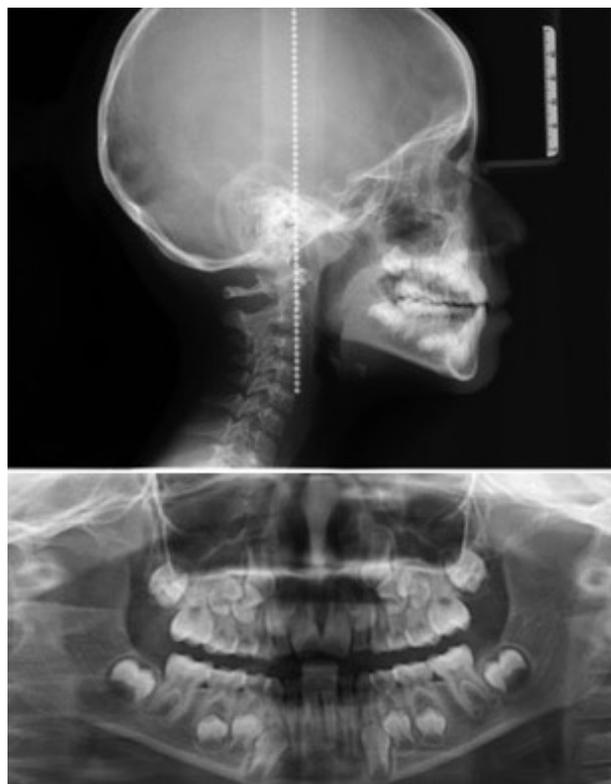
Imaging studies. Lateral skull radiograph, showing retroinclination of the incisors. Orthopantomography, showing dental crowding.
